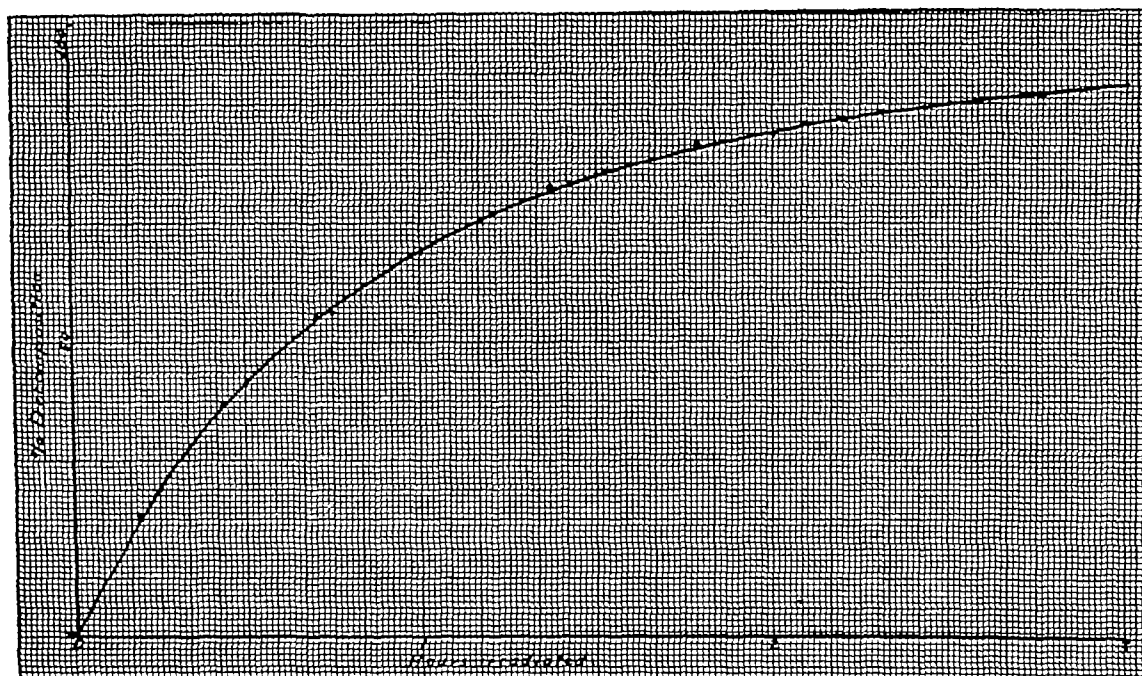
Relation between the length of exposure (in glass) of the solution to x-rays and the percentage changes of methylene blue. Circles refer to first series of experiments, dots refer to second series of experiments
